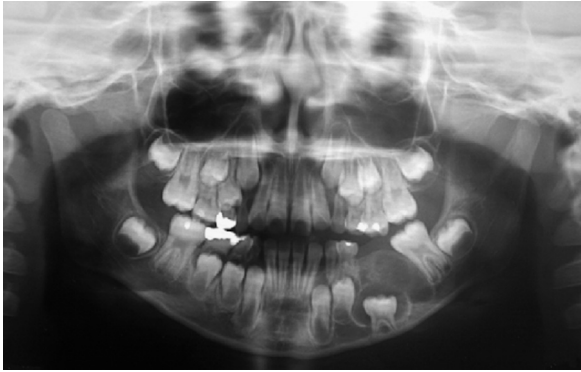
Panoramic radiography revealed well-defined radiolucency with a radiopaque area above the tooth crown of the unerupted deciduous second molar in the left mandible.
